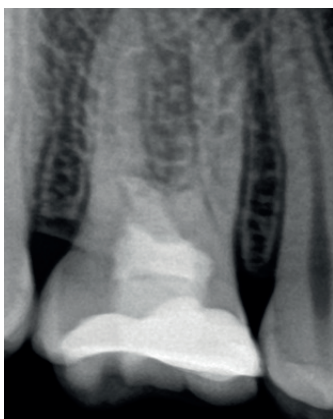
Periapical radiograph after 5 years. Note the evidence of root canal calcification.
